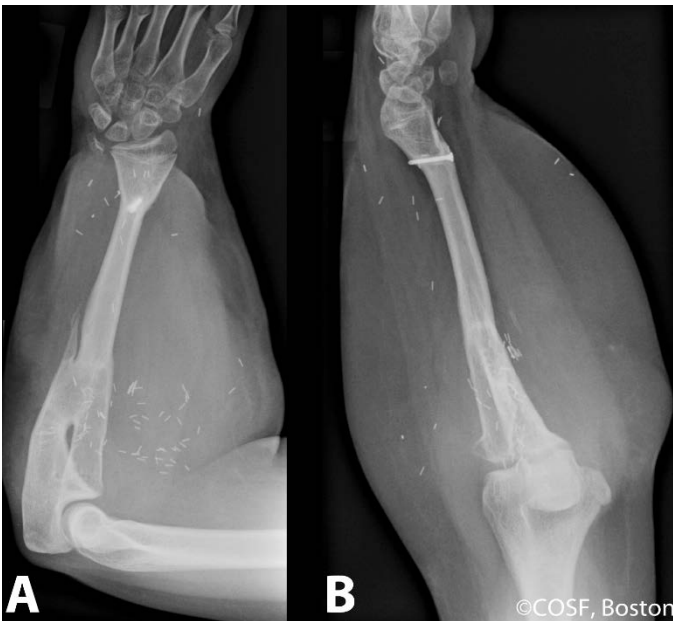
Anteroposterior (A) and lateral (B) radiographs of the healed single bone forearm.
